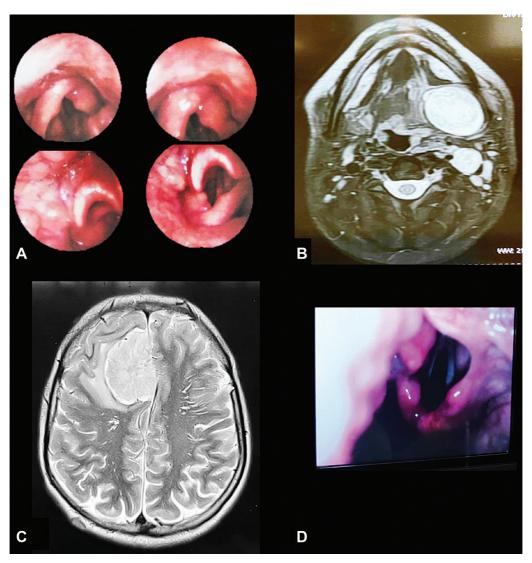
(A) Videostroboscopy view showing left vocal cord palsy, tubular epiglottis, and no sulcus. (B) MRI neck with contrast showing hypoglossal schwannoma. (C) MRI brain showing parasagittal meningioma. (D) Videolaryngoscopy view showing neurofibroma involving corniculate and cuneiform cartilage.
